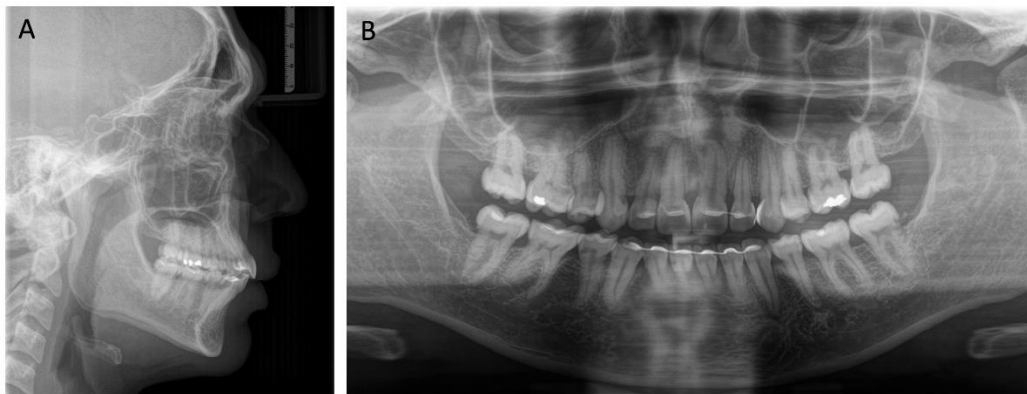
Five years follow-up lateral and panoramic radiographs.
